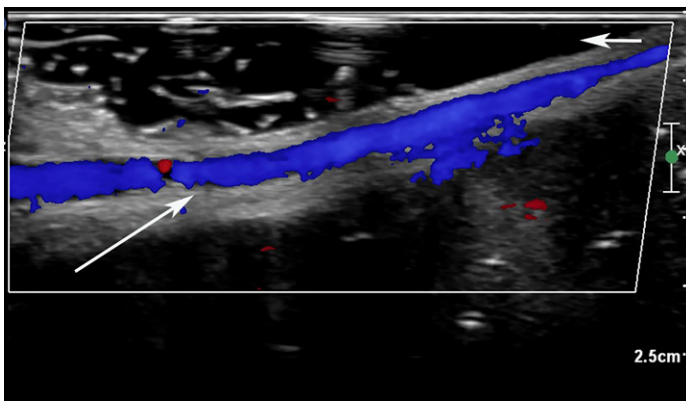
Color Doppler US longitudinal view of a normal dorsal penile vein (long arrow). Note that a copious amount of coupling gel (short arrow) acts as a standoff gel pad to minimize compression of the superficially located vein.
